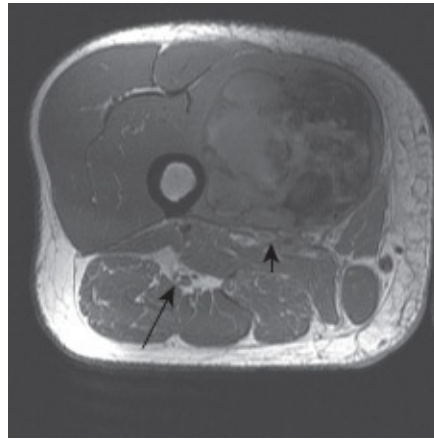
• Axial T1-weighted image demonstrating compartments of the thigh and relevant anatomy of the thigh. The *arrow* points at the sciatic nerve and the *arrowhead* at the femoral vessels, and there is a sarcoma in the vastus medialis.
